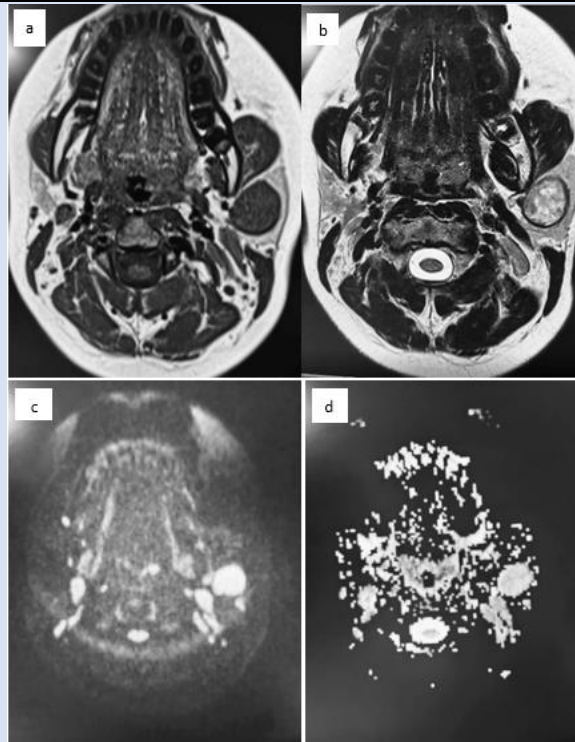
Facial MRI: axial section showing a mass of the left parotid gland measuring 24x21 mm, hypointense on T1, hyperintense on T2 and diffusion with ADC coefficient of 0.8, surrounded by a peripheral capsule with a hypointense on T1 and T2, as well as a peripheral enhancement after contrast injection. a: T1/b: T2/c:Diffusion/d:ADC coefficient
